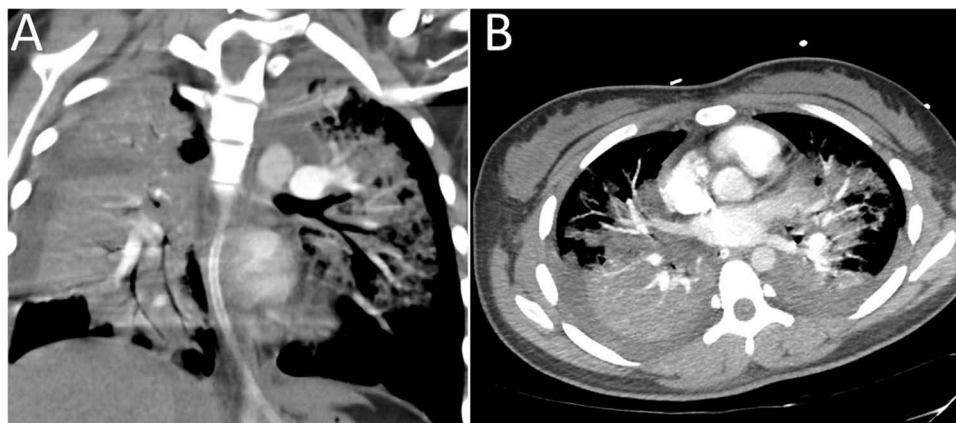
Follow-up chest CT scan one day after intubation. (A) Coronal view. (B) Axial view. Both images show bilateral lung opacities consistent with ARDS.
